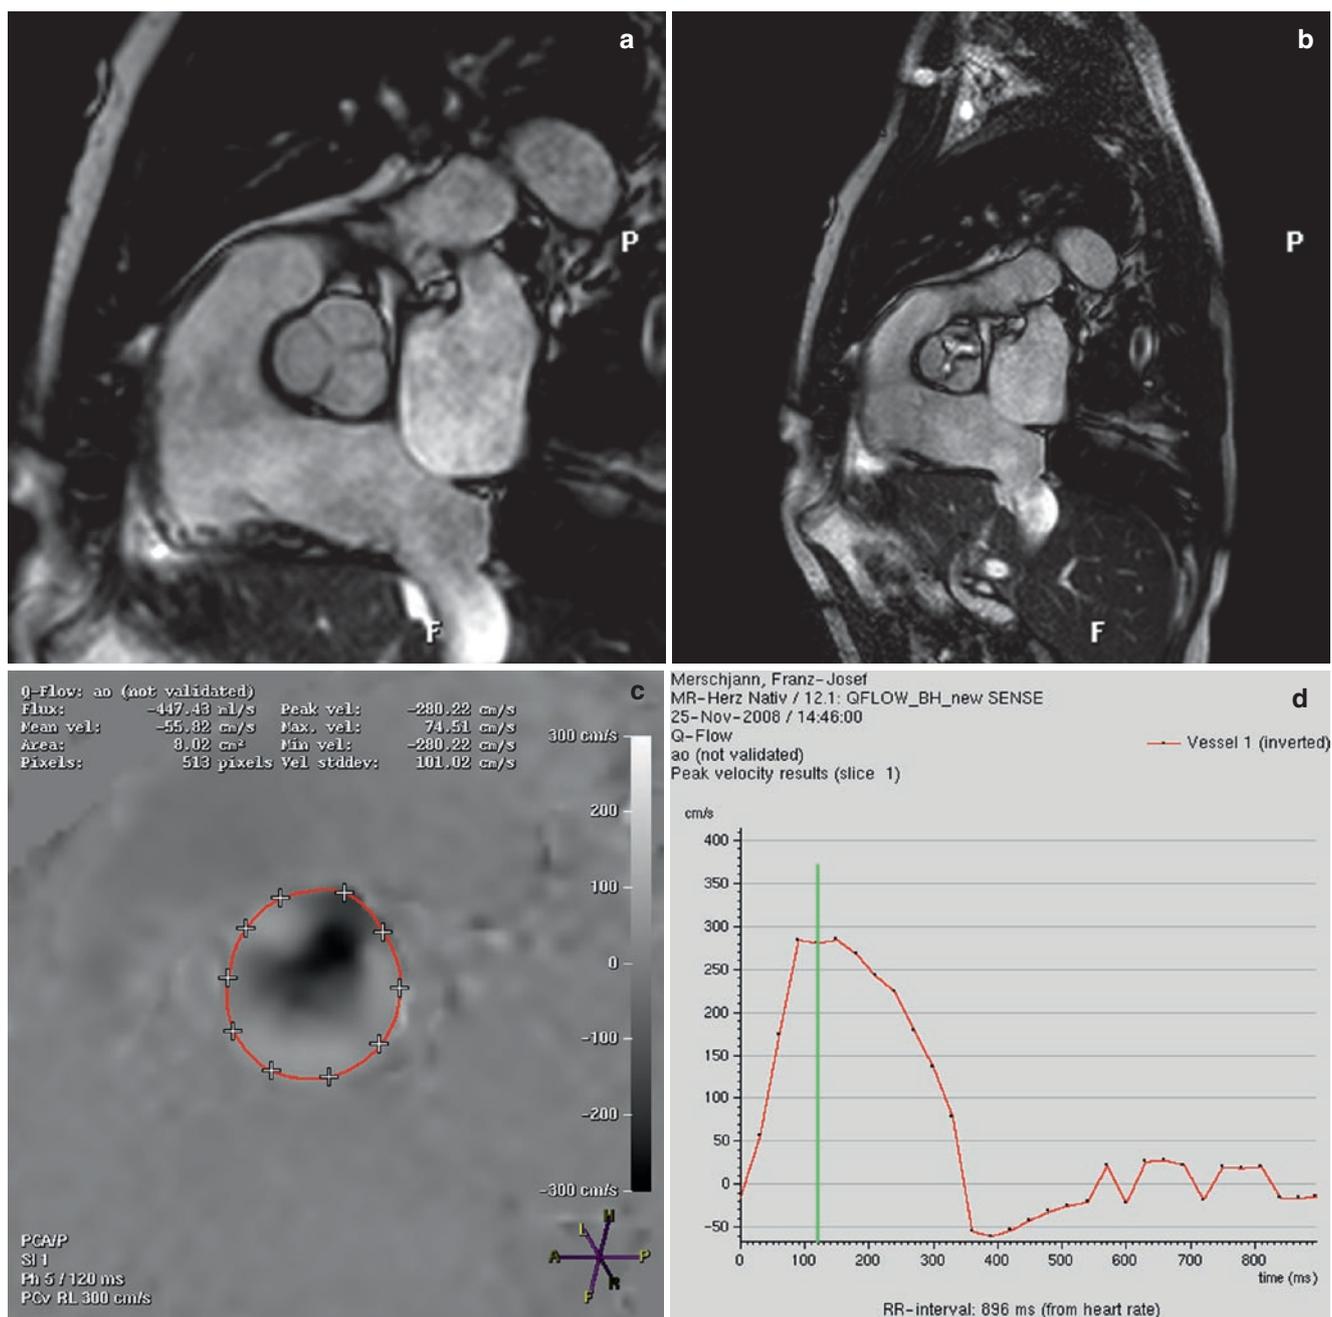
MRI of AS: Steady-state-free-precession MR images in diastole (a) and systole (b) show impaired opening of the valve and reduced valve area. (c) shows a phase-contrast image at a level 2 cm above the valve, (d) a time curve of peak flow velocity measurements
